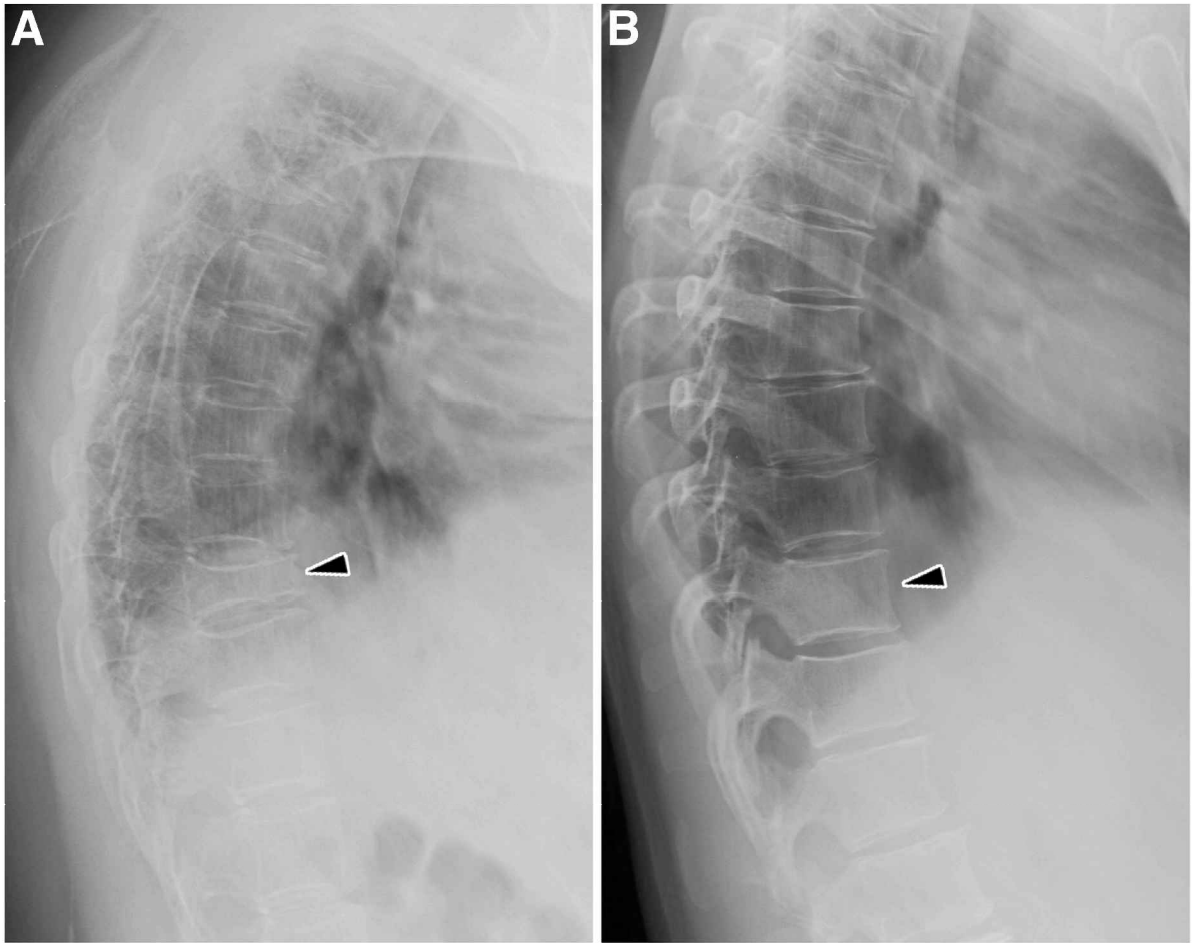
(A and B) Lumbar spine x-rays show the effects of ERT nonadherence on vertebral strength. The vertebral bodies of the 33-year-old woman (A) are deformed and compressed (especially T9, arrow), causing chronic pain, kyphosis, and decreased height.
